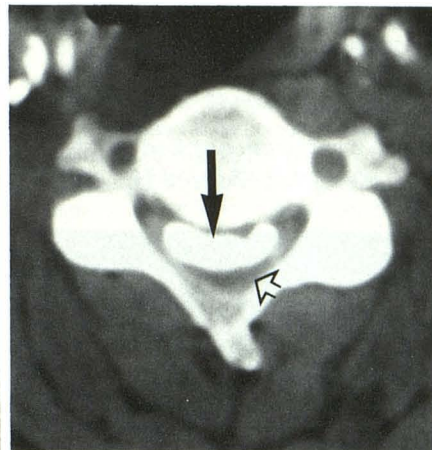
Axial CT scan with intrathecal contrast at same level shows extensive ossification (solid arrow) and a severely compressed spinal cord (open arrow) with narrowing of subarachnoid space.
